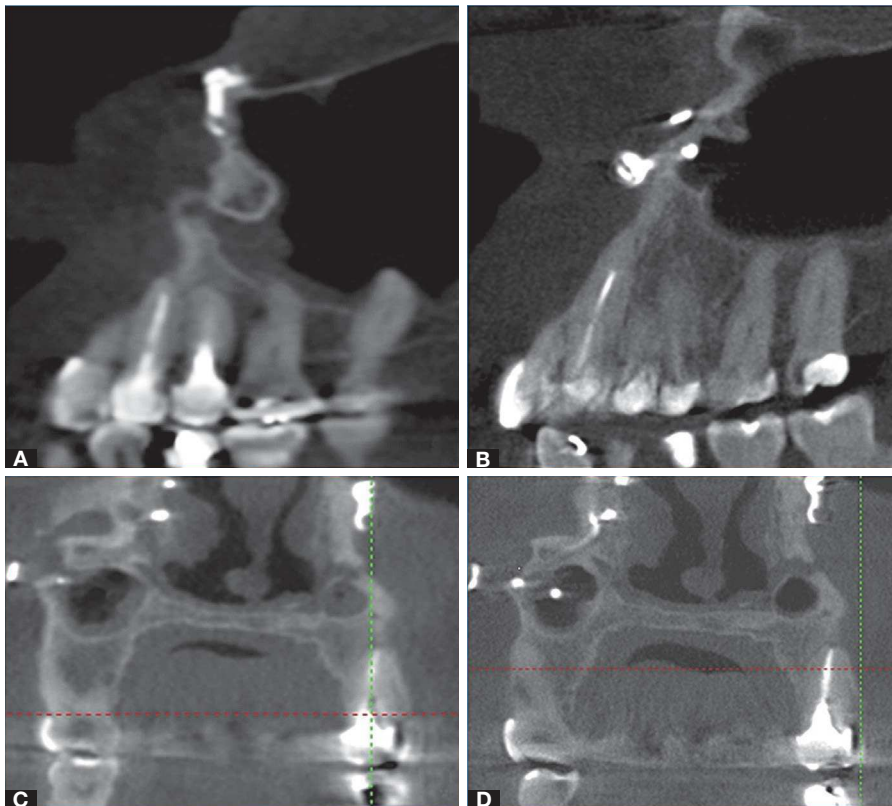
Axial scans of the relationship between posterior teeth and maxillary sinus: A) Initial CBCT; B) Control CBCT after medical treatment. Coronal scans of the relationship between posterior teeth and maxillary sinus: C) Initial CBCT highlighting right maxillary sinus anterior extension filled with mucosal inflammation; D) Control CBCT after medical treatment.
